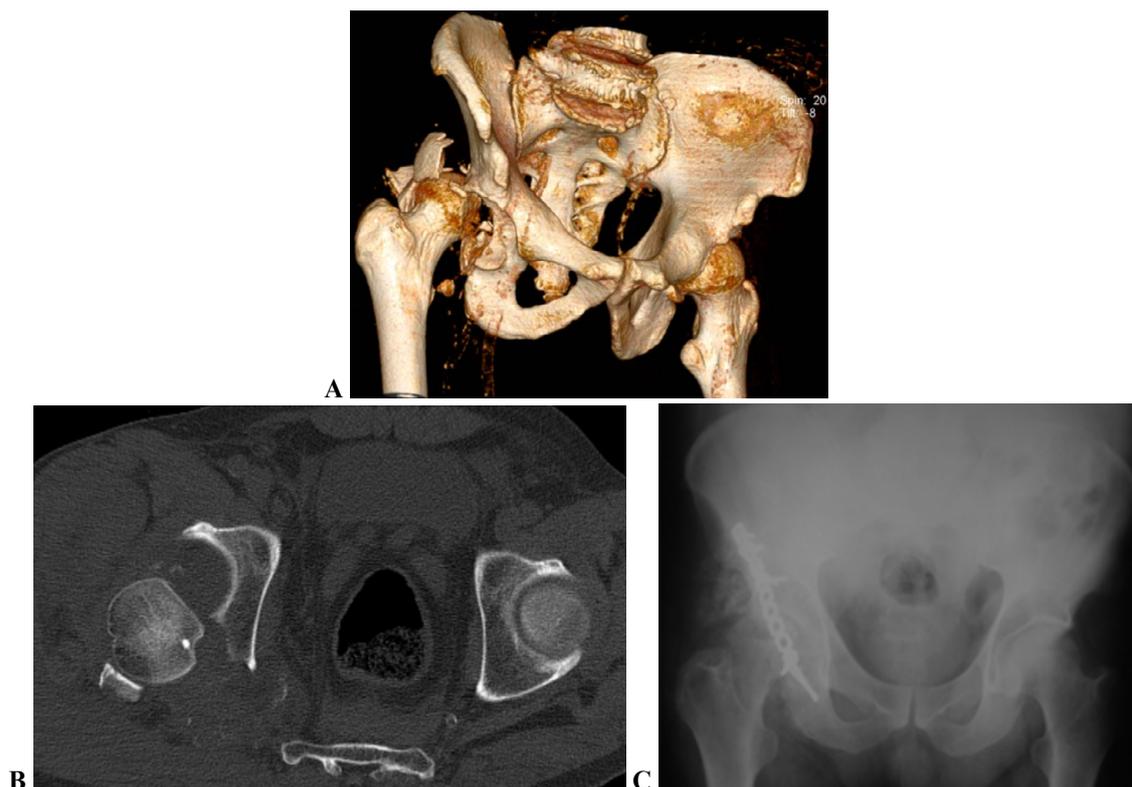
35 years old male patient. The initial CT showed postero-superior dislocation of the hip associated with a femoral head fracture (subfoveal) and posterior acetabular wall fracture – Pipkin type IV (A, B) that was treated surgical - open reduction and internal fixation of the acetabular fracture through posterior Kocher-Langenbeck approach and excision of femoral head intra-articular free bodies. C – six month follow-up X-ray – we observed heterotopic ossifications.
